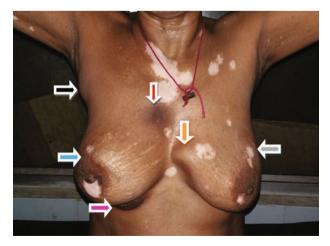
Nodules/Mass in the breast and chest wall. Erythmatous plaque over the right parasternal region(red), right breast mass (blue), right inframammary (pink), left parasternal (orange), left breast (grey).
